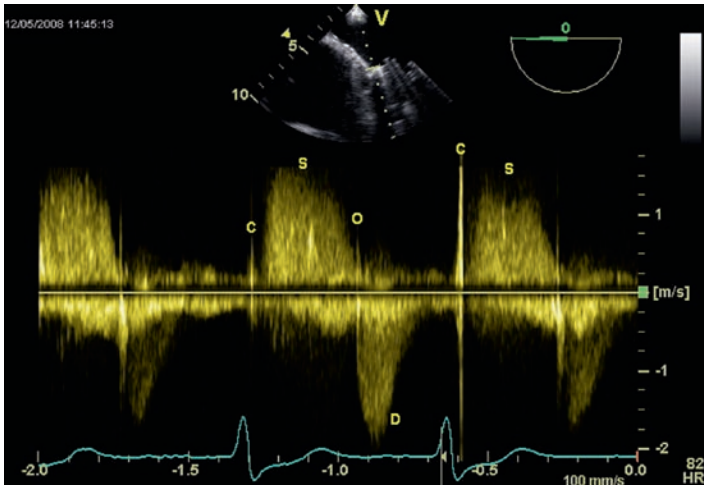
Continuous wave Doppler trace of a mechanical mitral valve replacement recorded from the mid esophageal 4 chambers view demonstrating high intensity opening (O) and closing (C) artefacts. The patient was in atrial fibrillation; there is normal (diastolic) forward flow (D) and an abnormal (systolic) reverse flow (S) due to a paravalvular leak.
